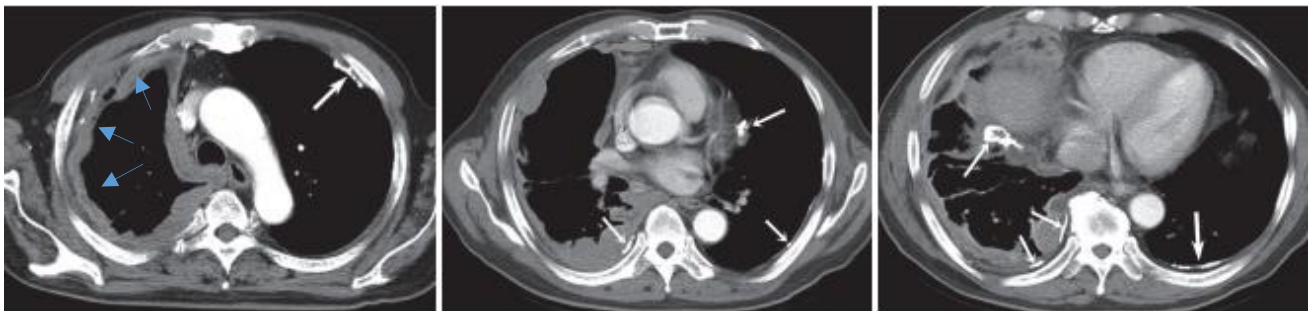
Transverse chest CT images of a 71-year-old man suffering from MPM
